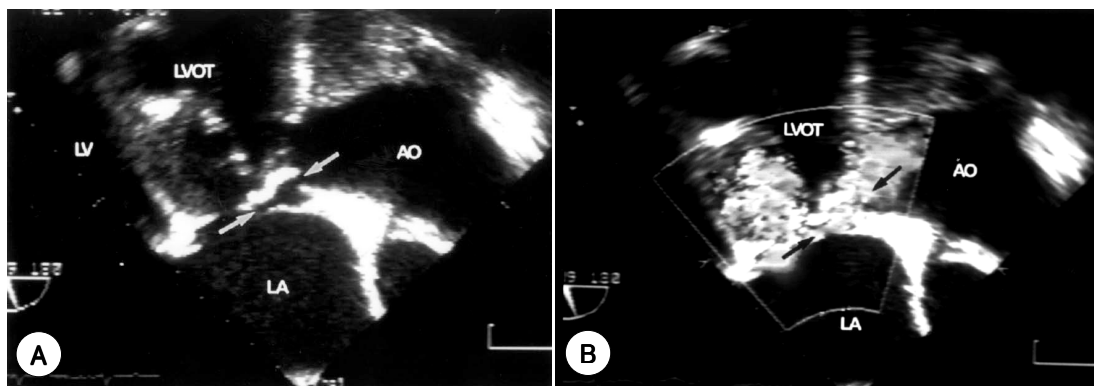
A : Transesophageal oblique four chamber view shows perivalvular cavitory lesion with fistulous connection to the aorta and left atrium. B : Transesophageal color doppler imaging reveals systolic turbulent flow through this cavitory lesion and demonstrates eccentric extension of flow jet to the left atrium.
